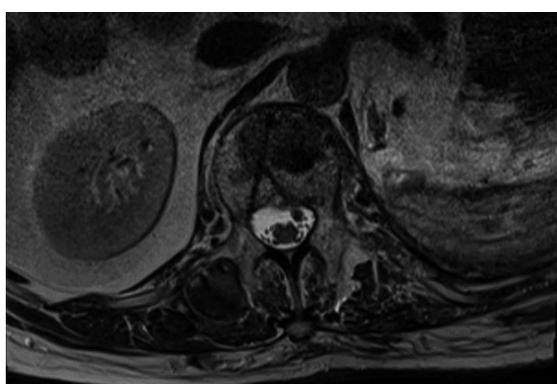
T2 weighed magnetic resonance imaging of the L1 vertebra on axial plane. As the image show, the trajectory of the needle used to perform the vertebroplasty passes within the spinal channel on the left side.
